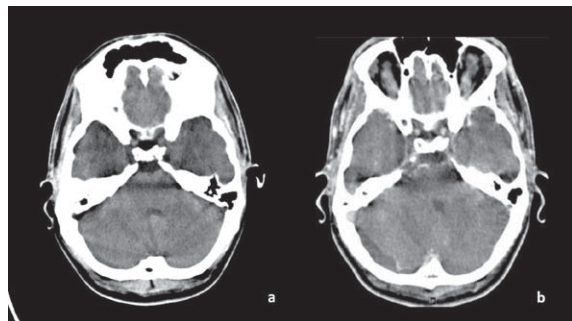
Figure 1a - Initial Head CT which was reported as normal. A small crescentic extraxial hypodense collection on right-side posterior fossa was already identifiable. Figure 1b - Head CT after clinical deterioration. Right-side posterior fossa collection growth (44x11 mm) with mass effect over right cerebellar hemisphere and fourth ventricle.
